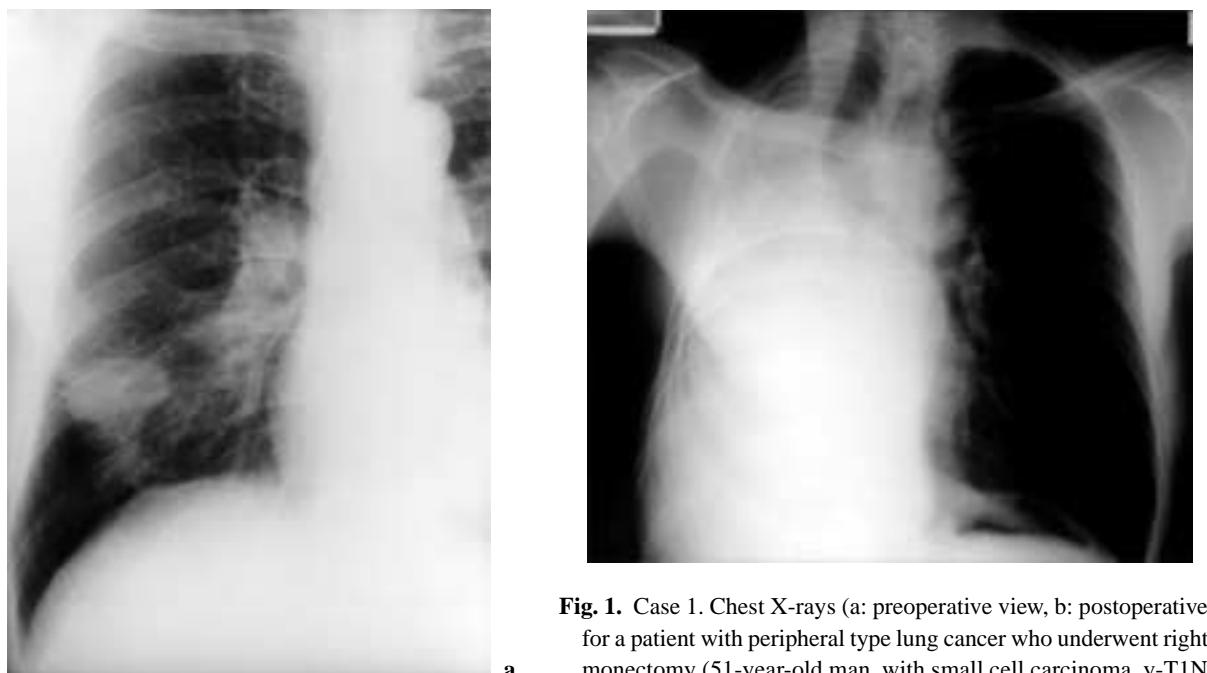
Case 1. Chest X-rays (a: preoperative view, b: postoperative view) for a patient with peripheral type lung cancer who underwent right pneumonectomy (51-year-old man, with small cell carcinoma. y-T1N2M0).
